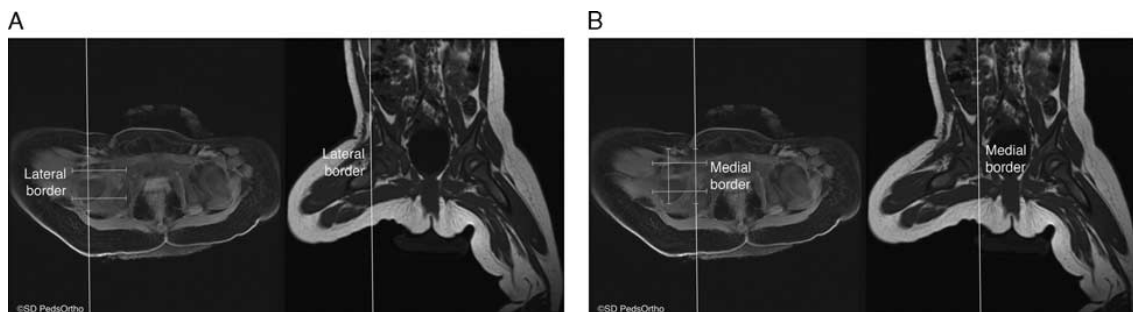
Axial (left image) and coronal (right image) in sync magnetic resonance images demonstrating how the lateral aspect of the joint on coronal is drawn on the axial sequence (A), followed by the medial aspect of the joint (B).
